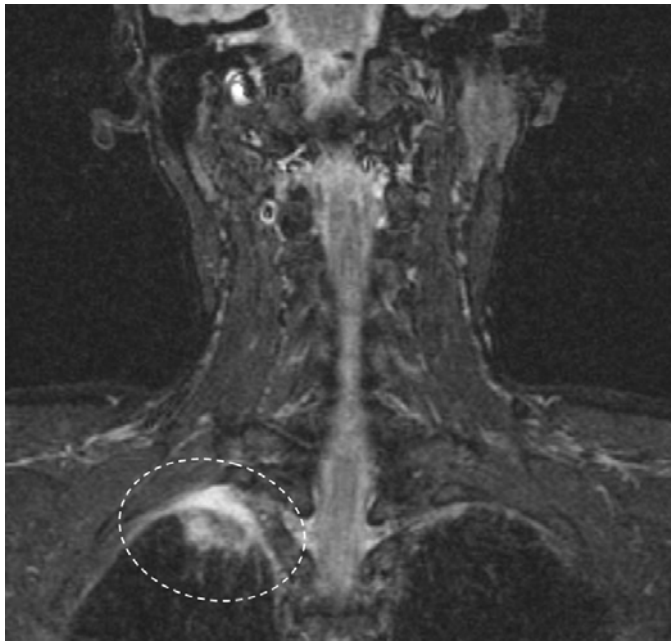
MRI ordered for cervical spine with incidental finding of right upper lung mass (dotted circle). This speculated area of increased signal explained the Pancoast tumor-like symptoms and led to the eventual diagnosis of *M. Xenopi*.
